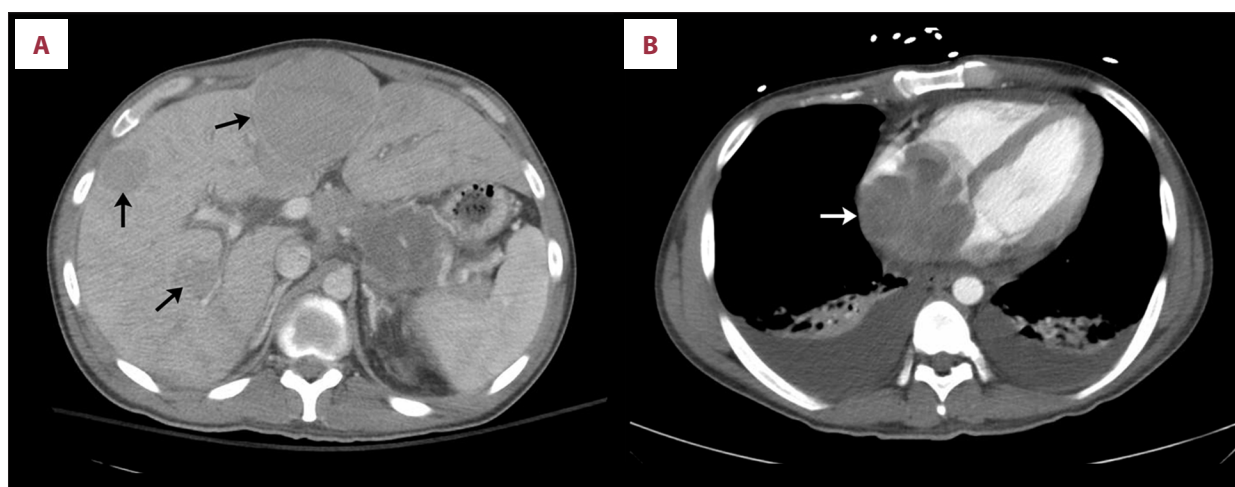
(A) CT scan of the abdomen and pelvis shows multiple, hypodense lesions in the liver (arrows). (B) CT scan of the chest shows the right atrial mass (arrow).
